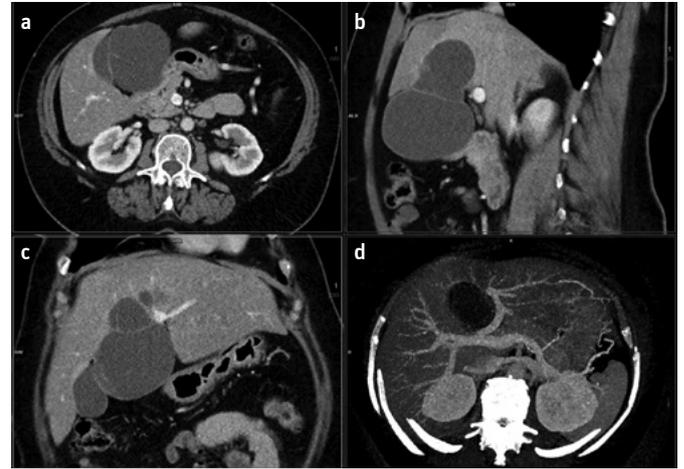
a-d. Cystadenocarcinoma propagating into the subhepatic space—image of topical relationships with the gallbladder, which is pushed laterally and dislocation of the left portal vein branch; (a) axial, (b), sagittal, (c) coronal multiplanar reconstructions (d) portal CT angiography using maximum intensity projection
